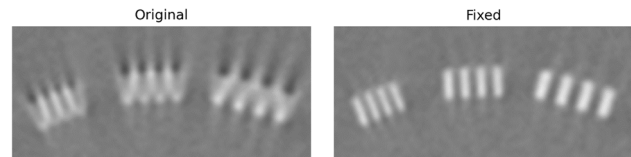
LFOV CBCT images of Catphan CTP528 module reconstructed using the original and corrected flexmaps
